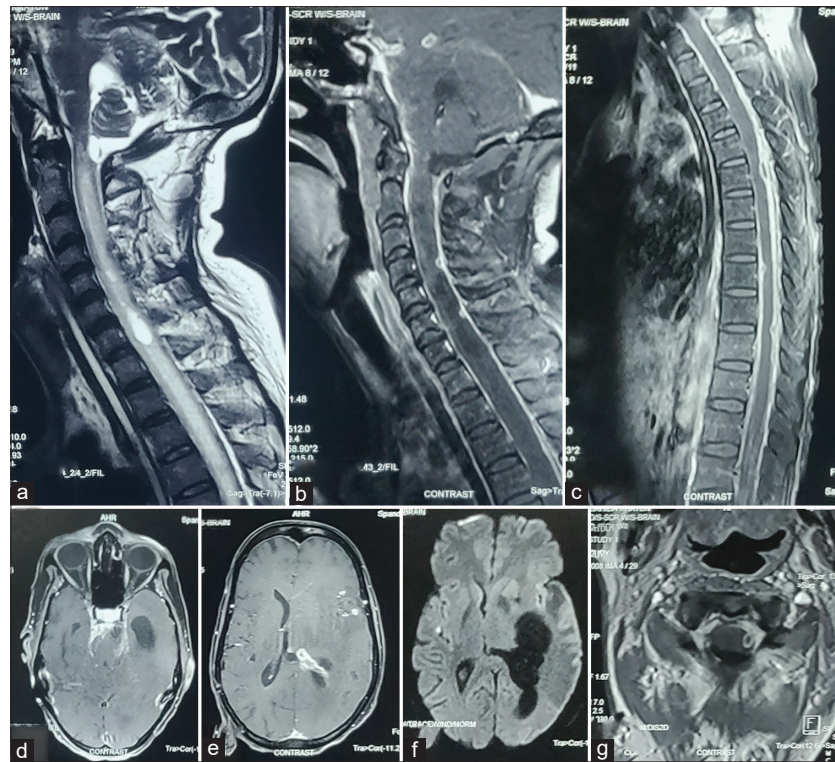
MRI spine (T2 weighted), sagittal section shows intra-medullary hyperintensities along the entire length of cervical and visualized dorsal spine suggestive of LETM along with cord swelling (a); T1-weighted postcontrast sequence, sagittal section shows multiple intramedullary ring enhancing lesions suggestive of tuberculoma along with meningeal thickening and enhancement (b); enhancement along the exiting nerve root (c); MRI Brain T1 postcontrast axial section showing diffuse enhancement of optic chiasm suggestive of opticochiasmatic arachnoiditis (d); thick-walled ring enhancement in left frontal and thalamic region suggestive of tuberculoma and enhancement along the ependymal lining of lateral ventricle suggestive of ventriculitis and enhancement of the meninges over the right frontal lobe suggestive of meningitis (e); DWI sequence shows small true restriction in the right parietal lobe suggestive of acute infarct due to tubercular arteritis with asymmetric dilatation of left temporal horn of lateral ventricle suggestive of hydrocephalus (f); T1-weighted postcontrast sequence, axial section in the upper cervical region shows intramedullary ring enhancing lesions suggestive of tuberculoma (g); MRI: Magnetic resonance imaging, DWI: Diffusion-weighted images, LETM: Longitudinally extensive transverse myelitis
